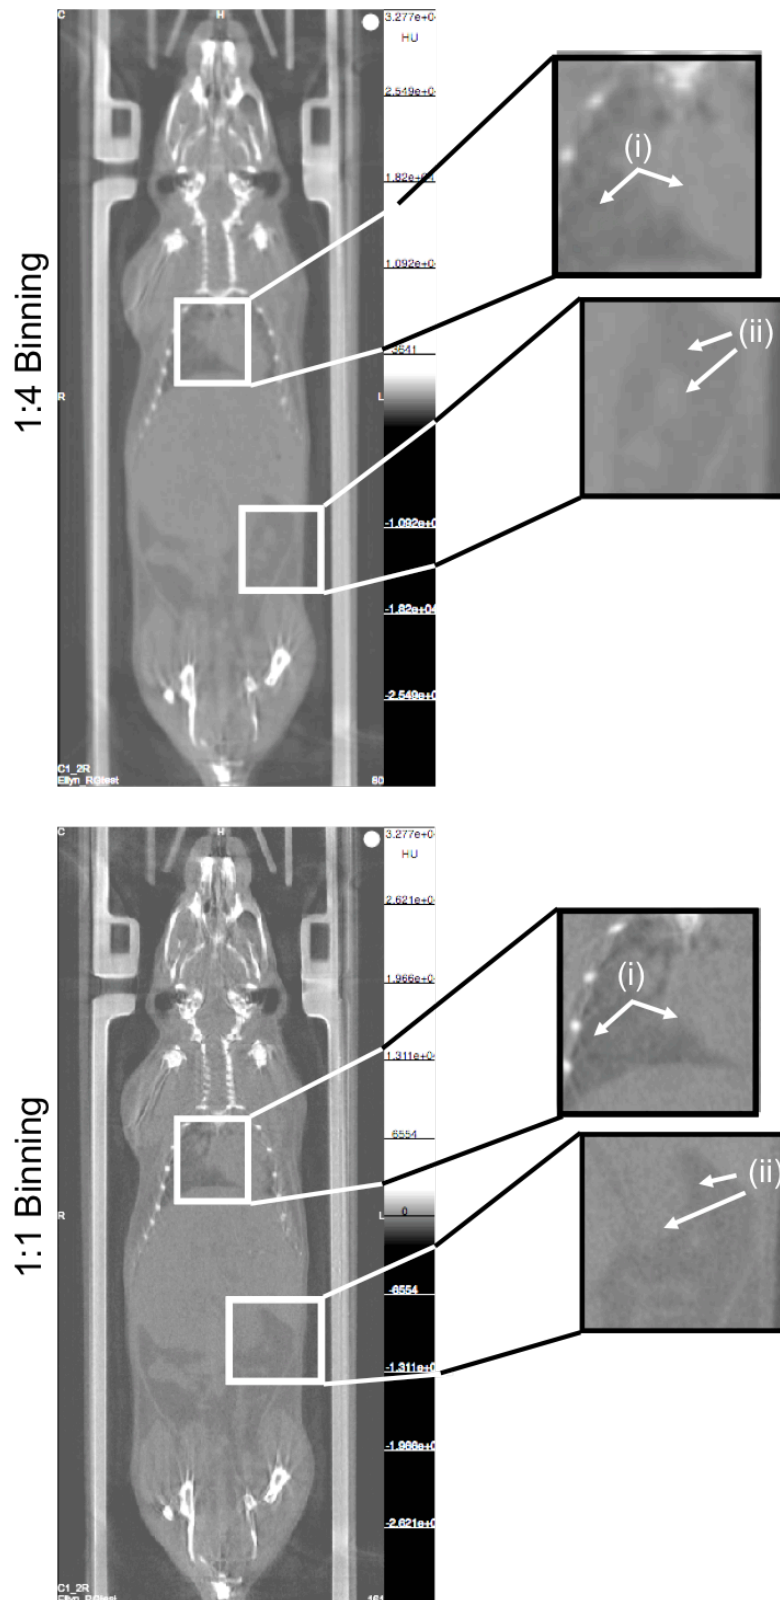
The binning process enhances the resolution of the final reconstructed CT image. A CT image acquired at 1:1 binning and subsequently reconstructed at 1:1 binning and 1:4 binning. White arrows indicate the difference in contrast between the heart and lungs (i) and some soft tissues in the abdominal cavity (ii). Each image has been artificially brightened by 26% using Microsoft PowerPoint™ to fully highlight the contrast observed in binning techniques.
